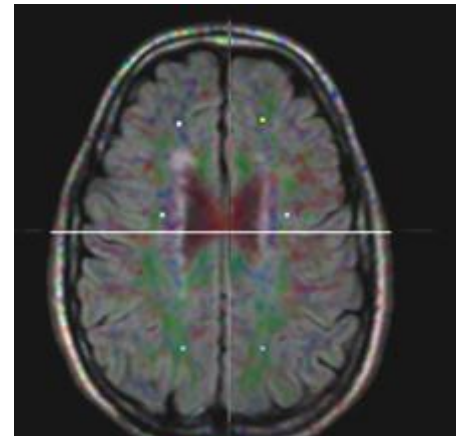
Case (2) fused FLAIR/DTI Axial image
